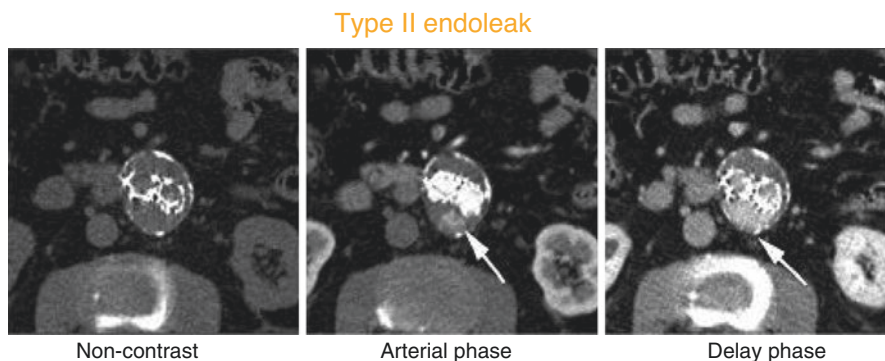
Axial CTA images demonstrate contrast extravasation in the posterior aspect of the excluded aneurysm on arterial phase that increases on delay phase but not present on pre-contrast images consistent with type II endoleak
